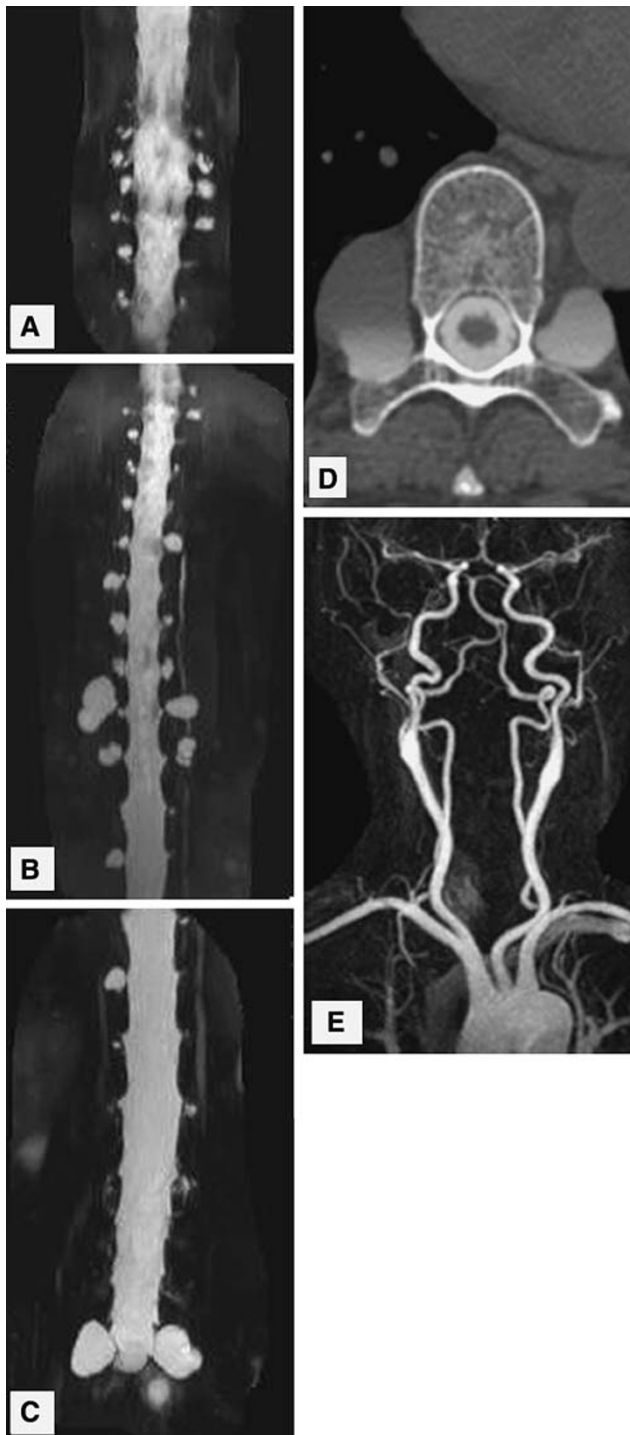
Imaging results for patient 4 (see Table 1). MR-myelography of the cervical (a), thoracic (b), and lumbosacral (c) spine showing numerous spinal meningeal diverticula. Post myelography CT showing large bilateral thoracic meningeal diverticula (d). MR-angiography showing tortuosity of both extracranial internal carotid arteries and the intracranial vertebrobasilar circulation (e)
